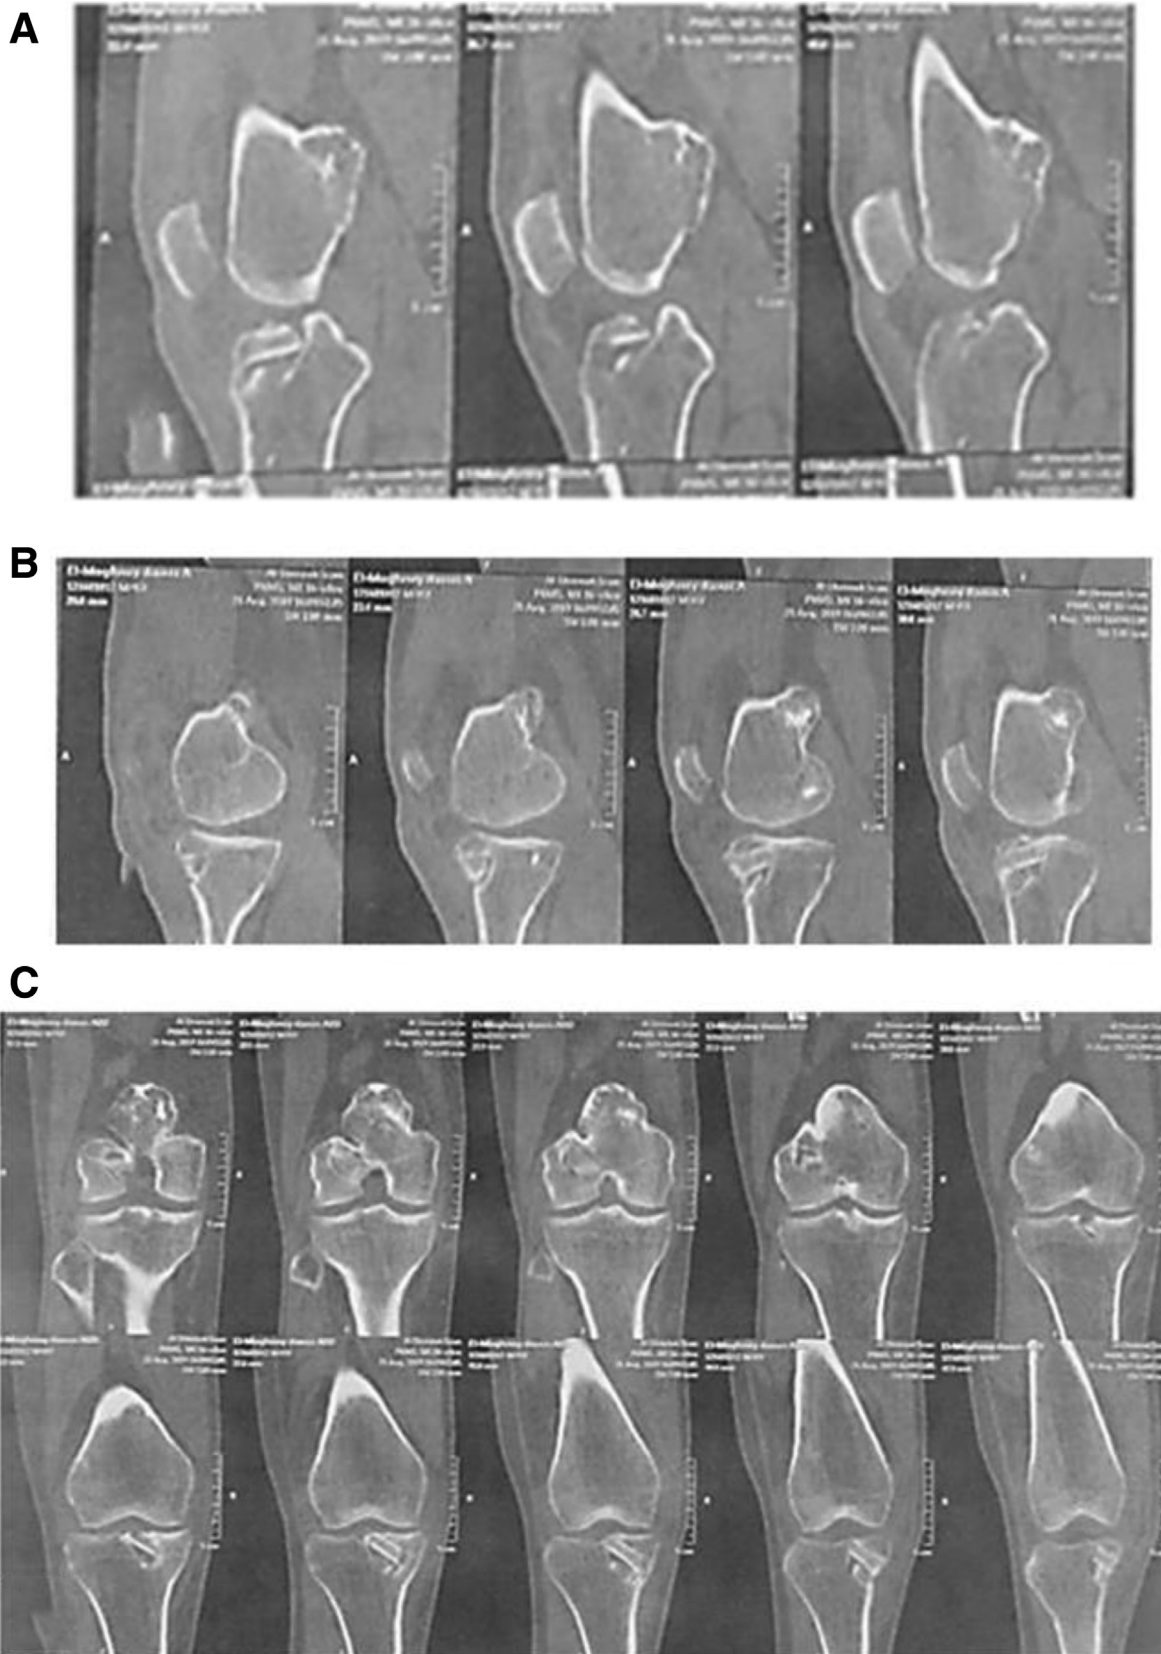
Computed tomography after 3 months. (A) Sagittal cuts showing graft incorporation into the tibial tunnel. (B) Sagittal cuts showing graft incorporation into femoral tunnel. (C) Coronal cuts showing graft incorporation into tibial tunnel.
